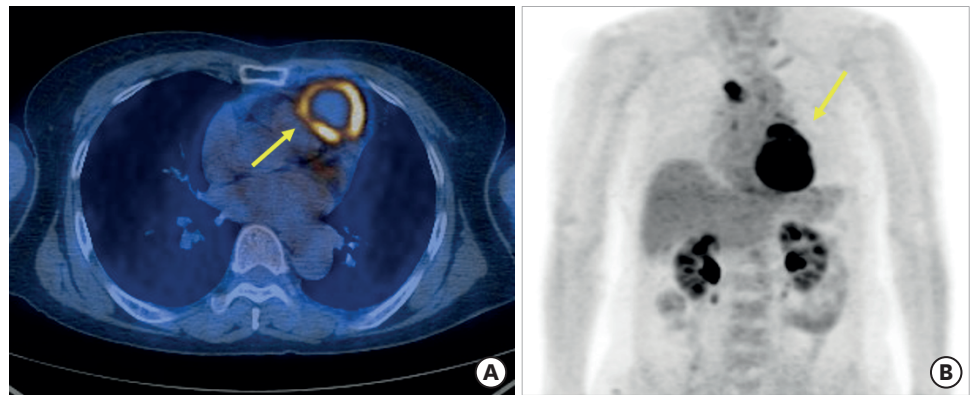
^{18}F -fluoro-deoxyglucose positron emission tomography with chest computed tomography showed a hypermetabolic mass (SUVmax = 10.4) with a central metabolic defect in the left anterior mediastinum (yellow arrow). Multiple hypermetabolic lymph nodes were detected in the paratracheal, subcarinal, hilar, and supraclavicular areas.
